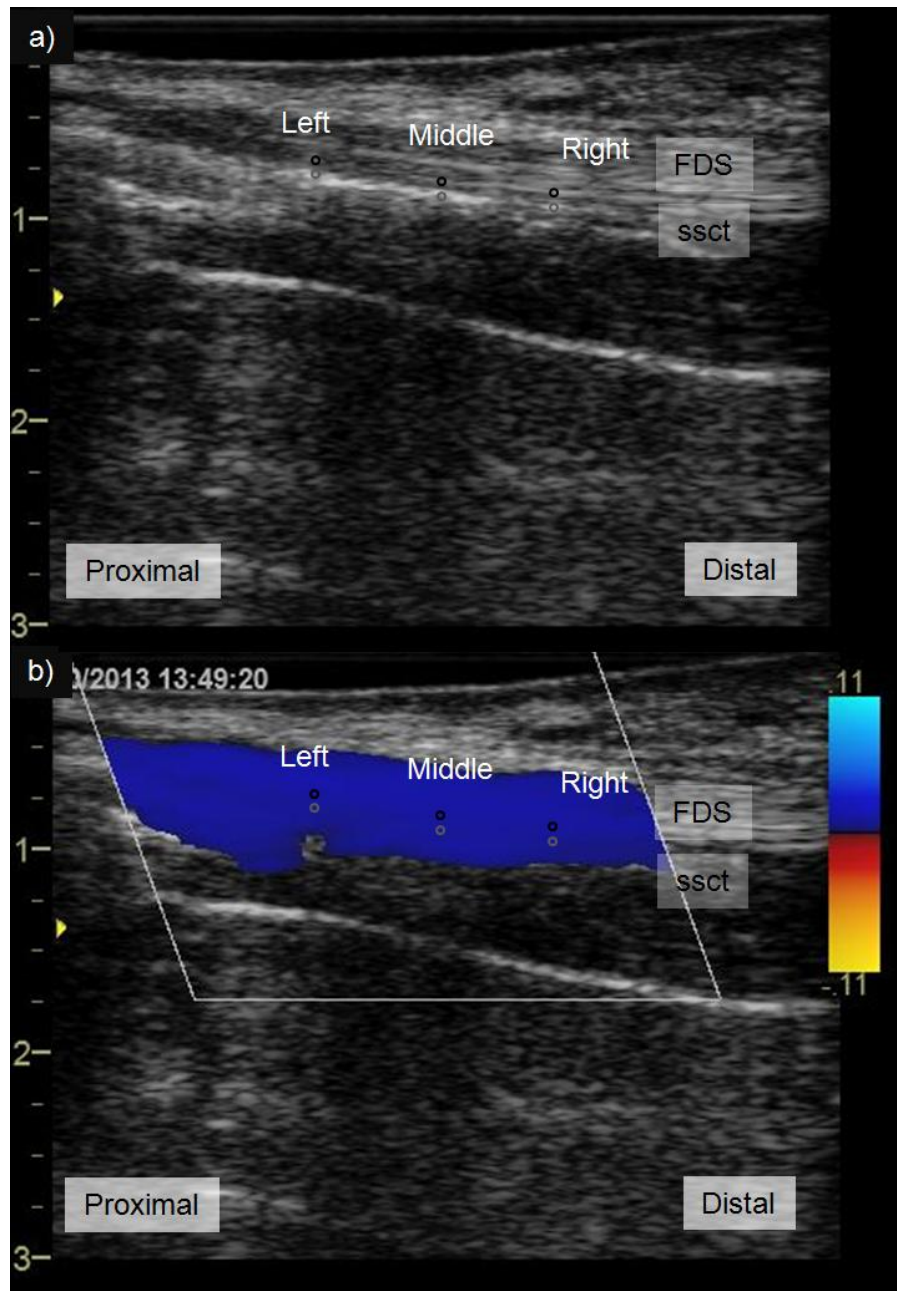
Ultrasound provided a simultaneous (a) grayscale echogram and (b) colour Doppler map of the middle tendon. The flexor digitorum superficialis (FDS) tendon is shown as a band of fibrillar striations bordered by a thin, bright subsynovial connective tissue (SSCT) layer. Pairs of markers were positioned at the left, middle, and right regions on the colour map. The top marker of each pair represented the tendon (black marker) and the bottom was the subjacent SSCT (gray marker). The blue colour map indicates flexion direction tissue movements.
